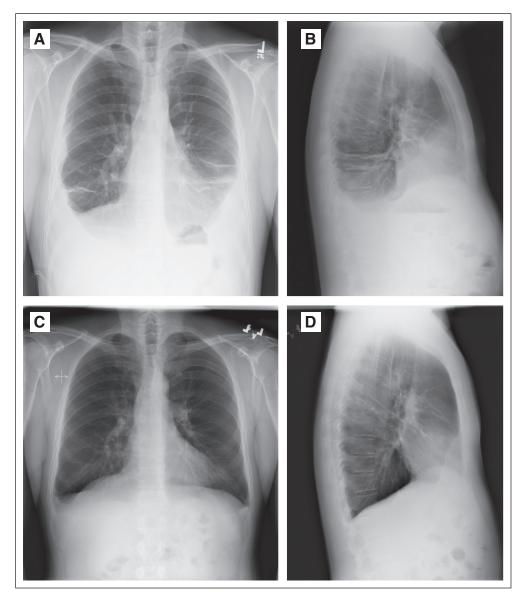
Resolution of a Kaposi's sarcoma (KS) -associated chylous pleural effusion in a patient receiving bevacizumab. A 44year-old man with HIV and KS had dramatic worsening of KS after starting highly active antiretroviral therapy, with development of greater than 50 cutaneous lesions, KS involving pelvic and inguinal lymph nodes, bilateral pleural effusions draining up to 6 L a week, and bilateral lower extremity edema. Analysis of the effusions did not reveal evidence of primary effusion lymphoma. The patient received 10 cycles of liposomal doxorubicin with some improvement in cutaneous lesions but no resolution of effusion, which required a right-sided indwelling pleural catheter. He also had continued lower extremity edema requiring daily diuretics. Within the first two cycles of bevacizumab, the effusions stopped draining, lower extremity swelling resolved, and diuretics were discontinued. (A) Posterior-anterior and (B) lateral chest x-rays at baseline. Bilateral pleural effusions and indwelling pleural catheter are on right. Pleural fluid was chylous (effusion triglycerides 1,905 mg/dL). (C) Posterior-anterior and (D) lateral chest x-rays at month 3 on bevacizumab. The effusions are resolved, and the indwelling catheter has been removed.
